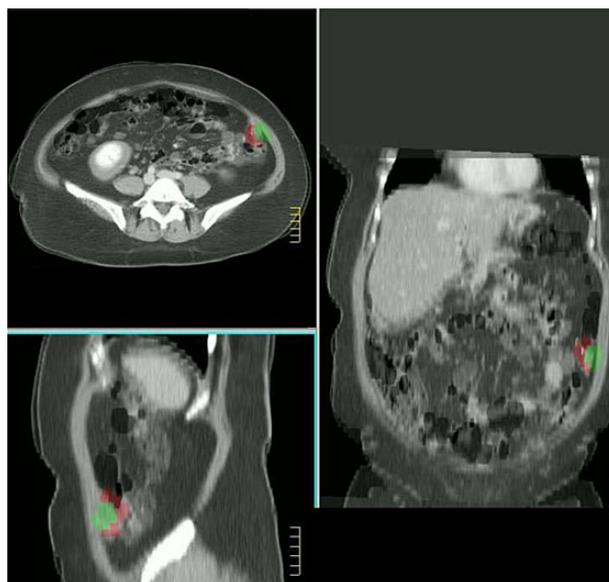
Superimposed pelvic CT images. Two images taken at different times were matched on bony structures. The differences in ovarian position (red and green lines) between CT images were measured.
